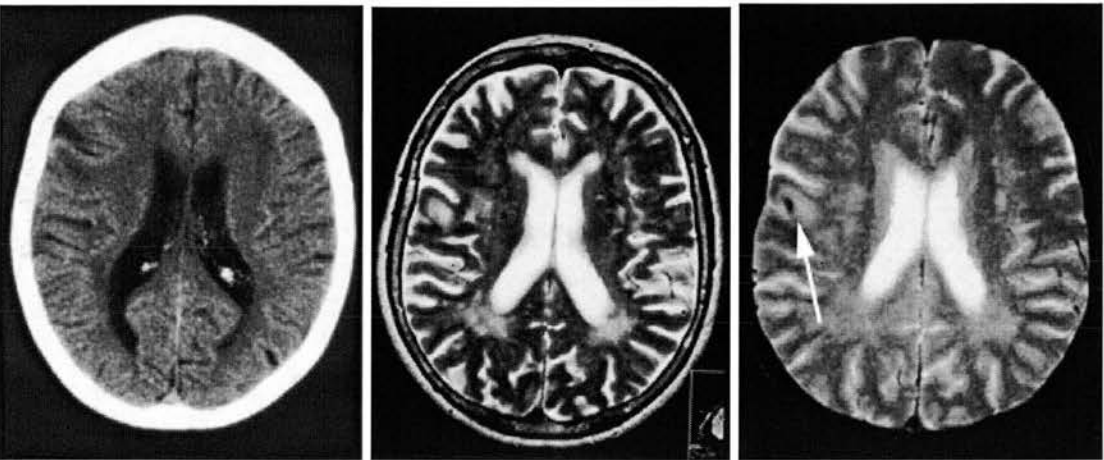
70 year old woman with right homonymous hemianopia, no residual signs. Scanned at 28 days. CT on left, gradient echo on right.
